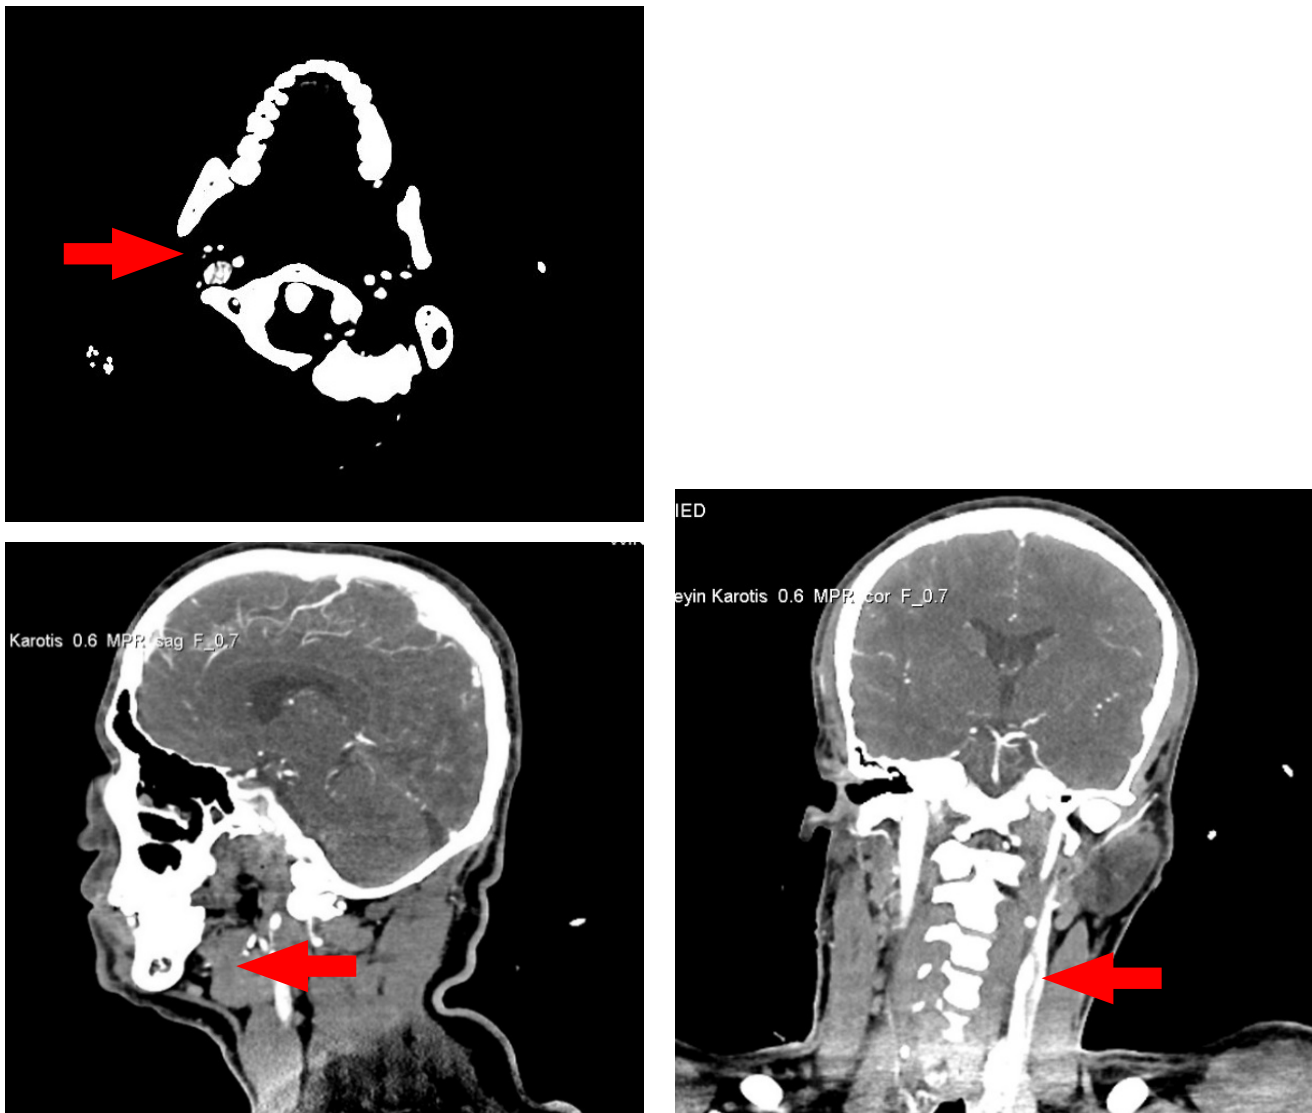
An appearance compatible with dissection in the patient's brain+cervical CT angiography
